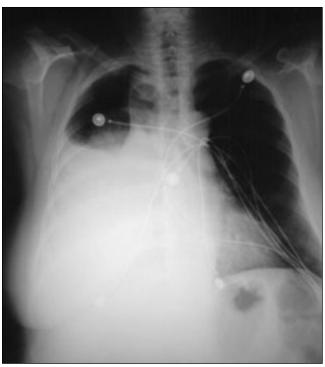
A posterolateral chest radiograph showing a massive rightsided pleural effusion
